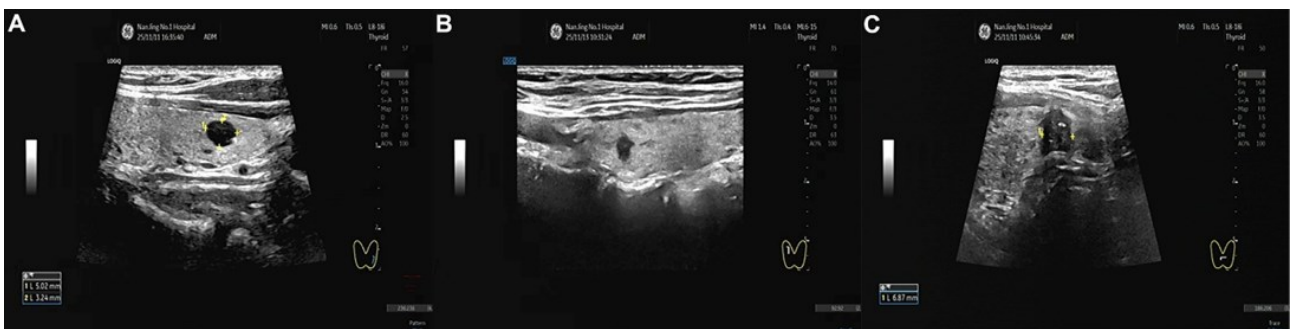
Ultrasound images of (A) benign, (B) suspiciously malignant, and (C) malignant thyroid nodules.
